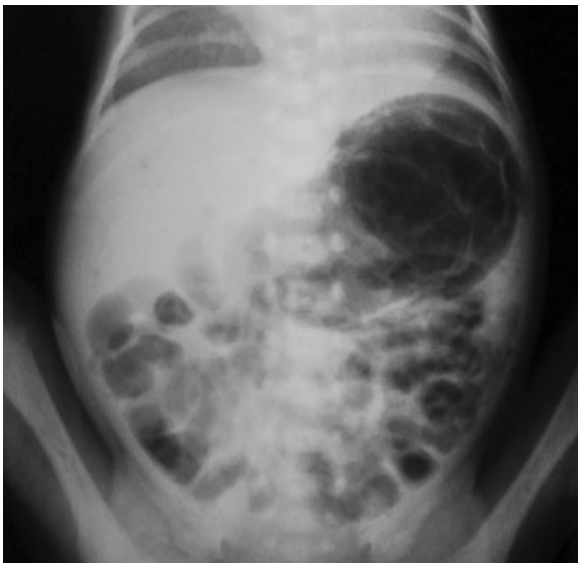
Abdominal X-ray of our patient showing gastric pneumatosis.
